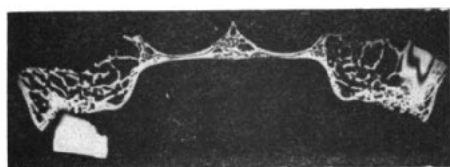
Soft x-ray radiograph of an undecalcified section through the midpalatal suture.
